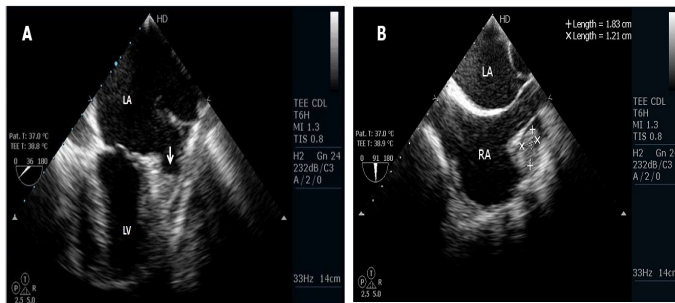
Biatrinal appendages clots. A: Transesophageal echo (TEE) showing clot in Left atrial appendage (arrow). B: Bicaval TEE view showing clot in Right atrial appendage.
